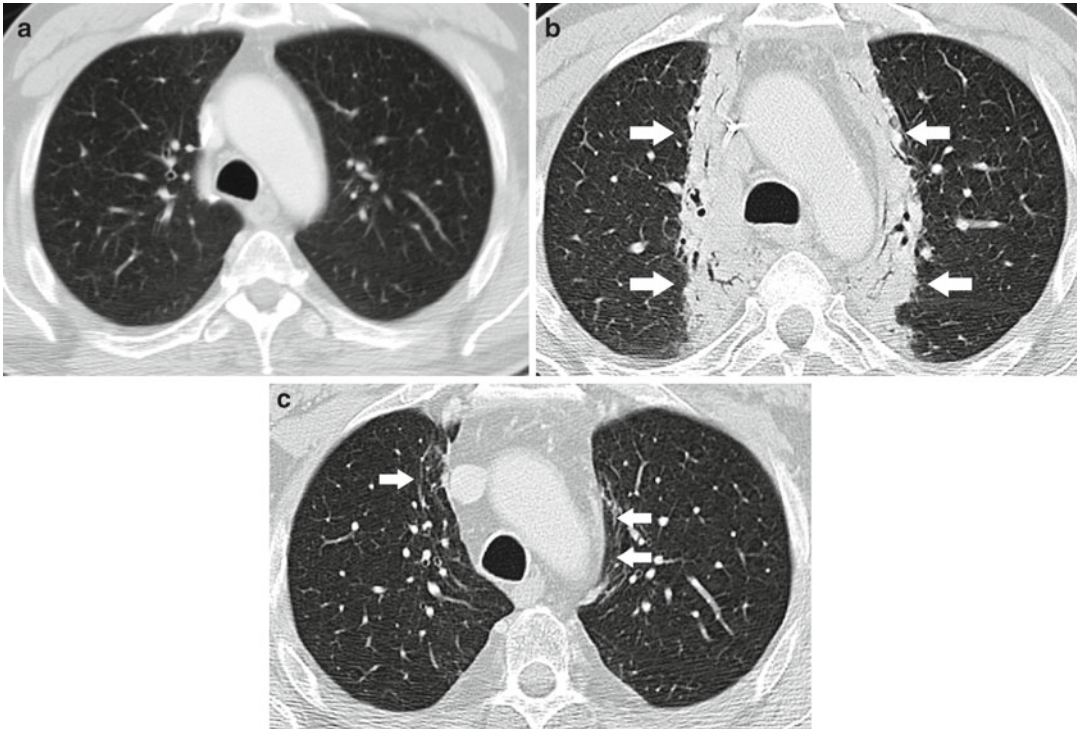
Recall radiation pneumonitis developing after chemotherapy in a patient who received mediastinal radiation 2 years earlier for non-Hodgkin lymphoma. (a) Image from CT scan before chemotherapy shows normal lung. (b) Image from CT scan obtained 2 weeks after chemotherapy
